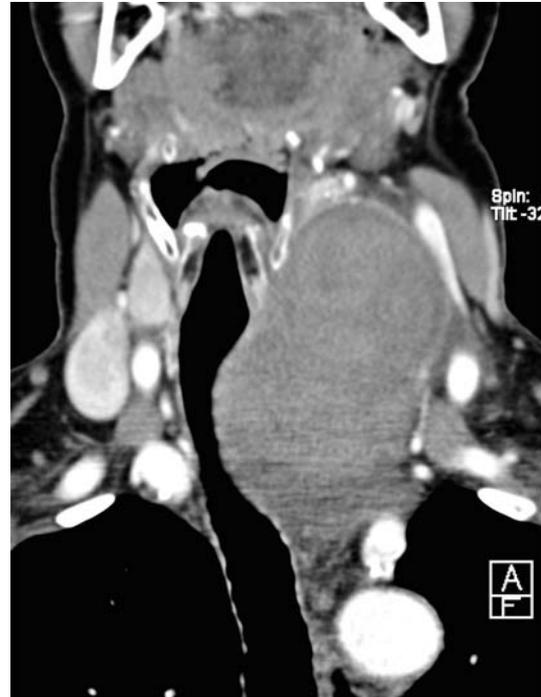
CT scan (a coronal maximum intensity projection and multiplanar reconstruction) of the anterior neck showing left thyroid hematoma compressing and deviating the trachea to the right side.
